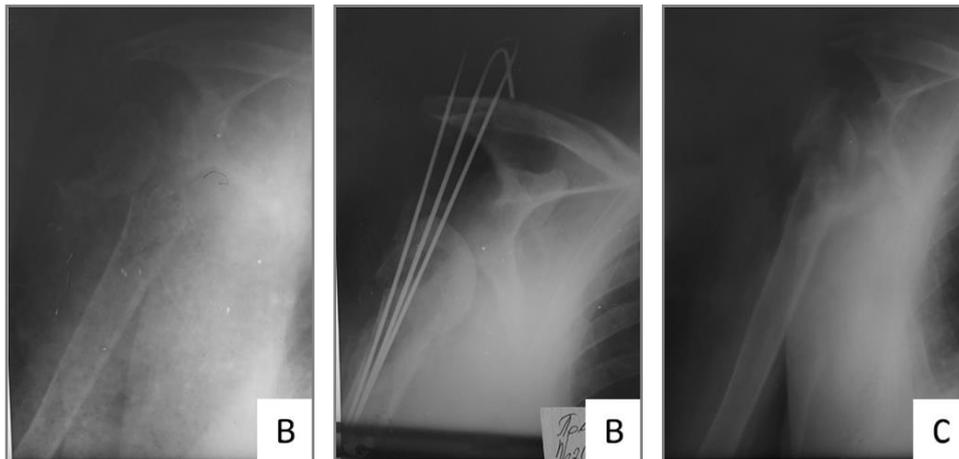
X-ray of patient M., 63 years, before and after osteosynthesis with pins: before surgery (a), after surgery (b), 3 months later after pins were removed (c).
